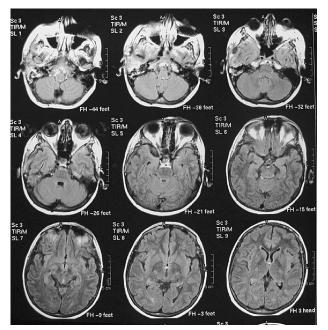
Repeated magnetic resonance imaging 1 month after beginning chemotherapy revealed a significant shrinkage of the right base mass lesion and disappearance of all other cranial masses.
